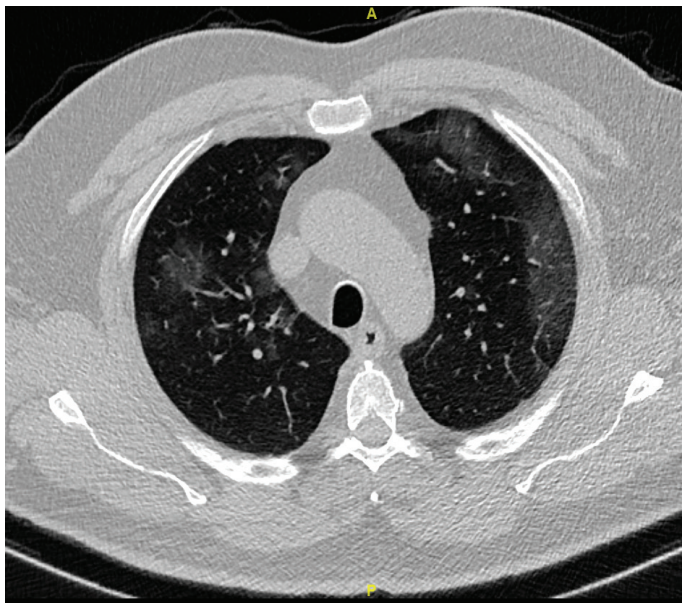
Computed tomography reveal ground glass appearance with bilateral infiltration in the lungs.
